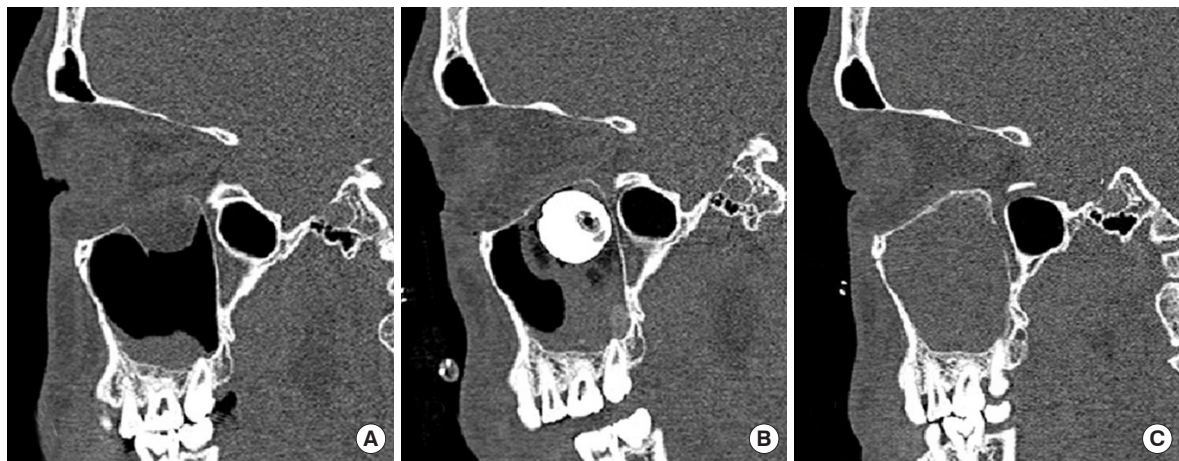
A 25-year-old man with a right inferior orbital wall fracture who underwent posterior ridge restoration with transnasal balloon-assisted support. (A) Preoperative computed tomography (CT) scan. (B) Immediately postoperative CT scan demonstrating balloon support within the maxillary sinus. (C) Six-month postoperative CT scan showing restoration of the posterior orbital floor contour.
